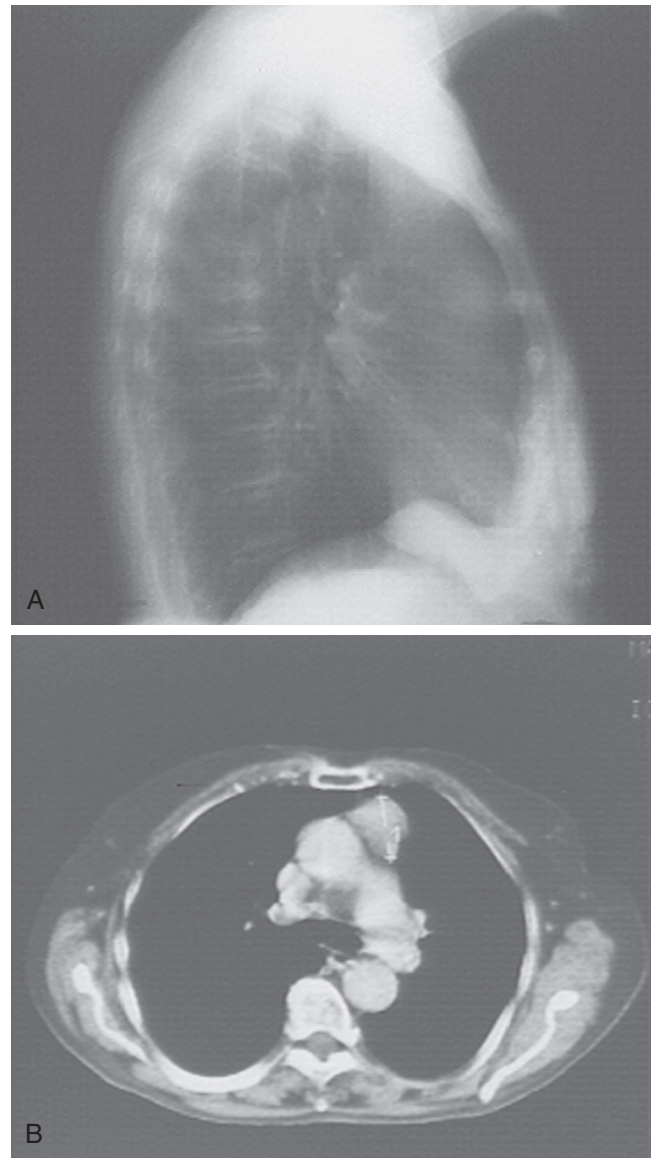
■ Primary pulmonary thymoma. In rare cases, when the tumor is extensive, radiation therapy may be a good alternative. A, Lateral chest radiograph of a pulmonary thymoma. B, The corresponding CT scan image.
